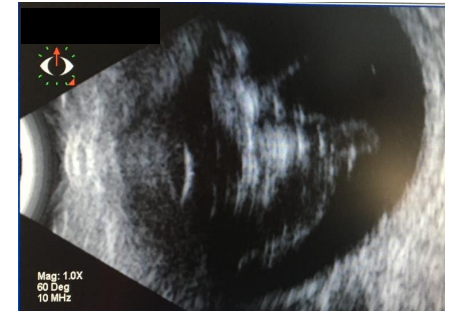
B-SCAN OCULAR ULTRASOUND OF A PATIENT WITH ENDOPHTHALMITIS. NOTICE THE VITREOUS CAVITY FILLED WITH MILD TO MODERATE AMPLITUDE POINT ECHOS AND THE PRESENCE OF POSTERIOR VITREOUS DETACHMENT.
